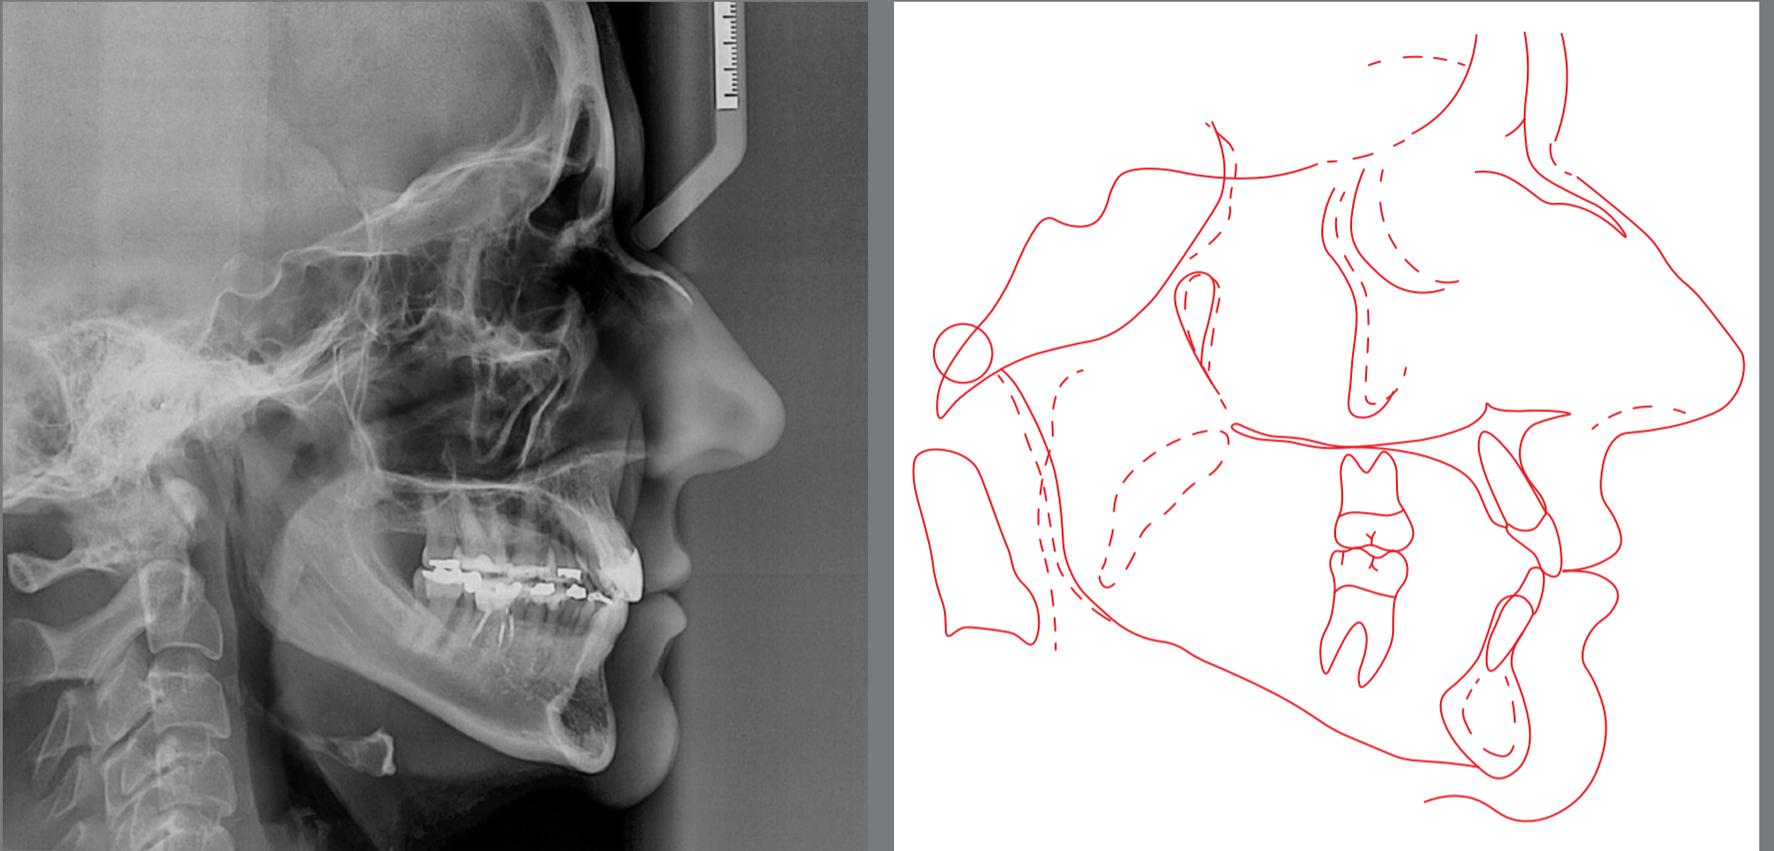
Final cephalometric radiograph and cephalometric tracing.
